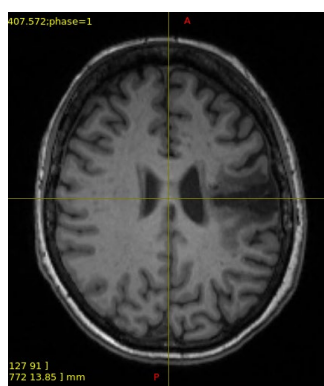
T1w stroke MRI image.
